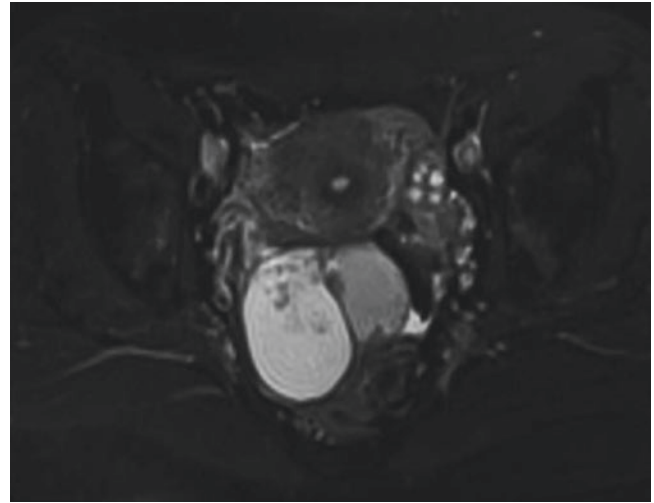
2 Axial contrast-enhanced T1WI fat suppression image showed significant papillary nodule enhancement. Sagittal delayed contrast-enhanced fat-suppressed T1-weighted image showed significant papillary nodule enhancement similar to that of the myometrium
